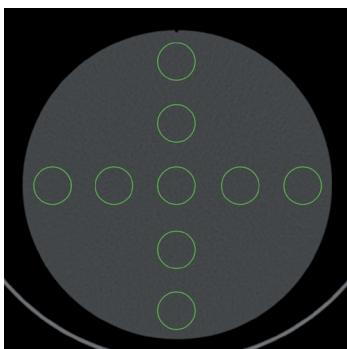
CT Image showing homogeneity analysis
